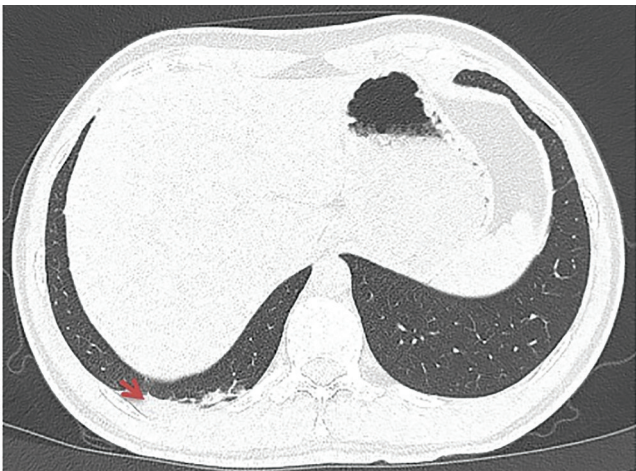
Follow-up pulmonary CT examination after one month, showing the marked regression of the ground-glass opacity, with no new or outstanding vascular filling defects being identified.
